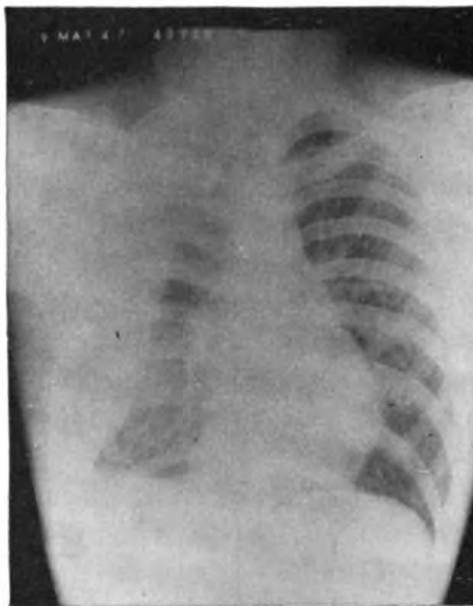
Case 6. Roentgenogram taken prior to operation. The large pleural collection on the right is demonstrated.
